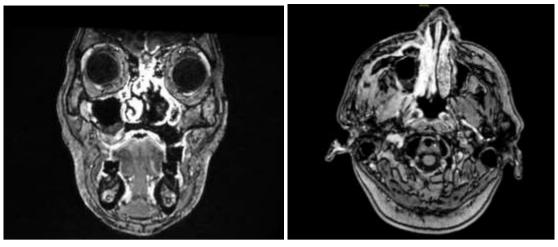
MRI imaging showing the presence of the "Black Turbinate Sign" as an early diagnostic feature of nasal mucormycosis
